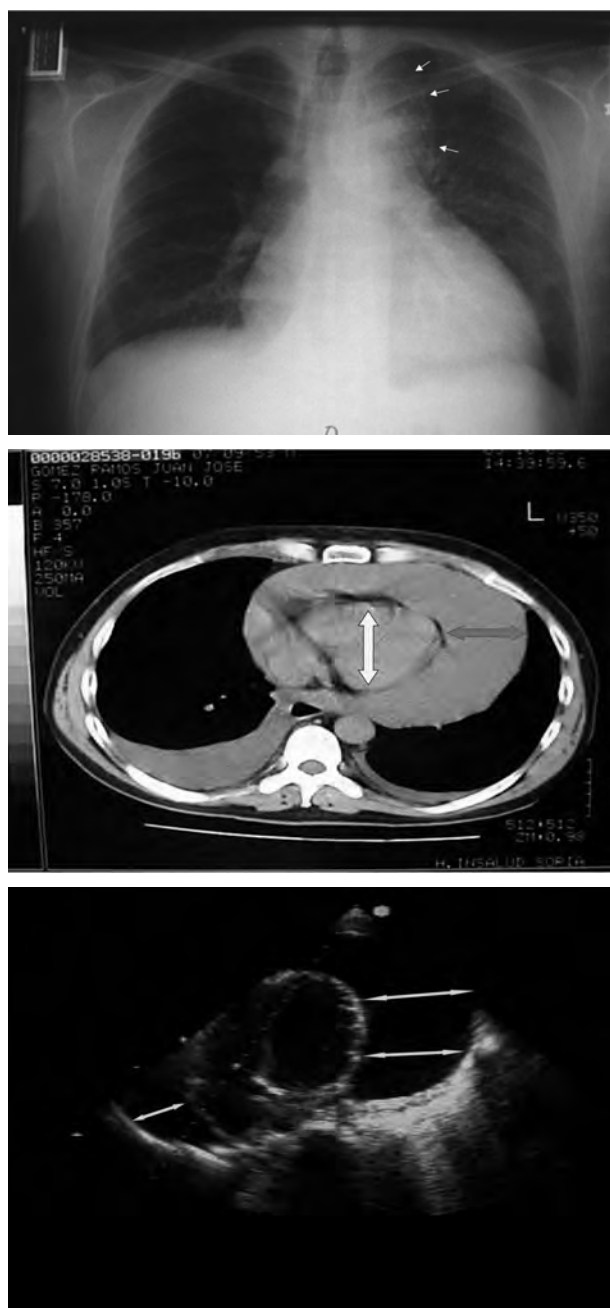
Pericardial effusion observed on chest x-ray (top, arrows indicate the loss of left lung volume), in the computerised tomography (centre, arrows) and in the echocardiography (bottom, arrows).
